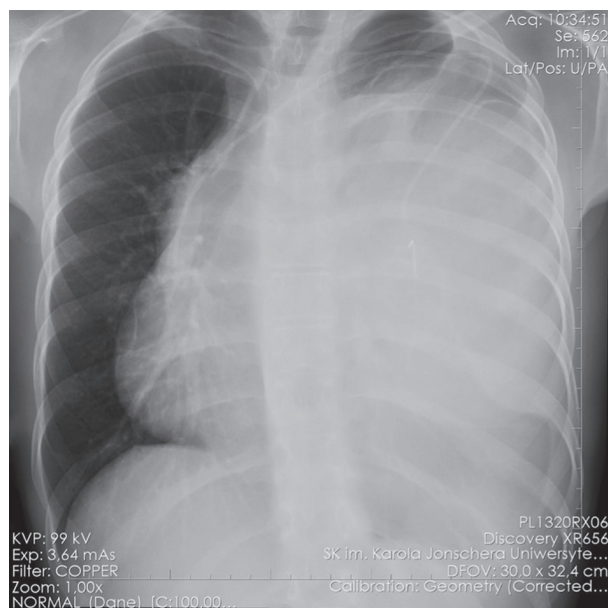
Chest X-ray demonstrating complete opacification of the left lung
